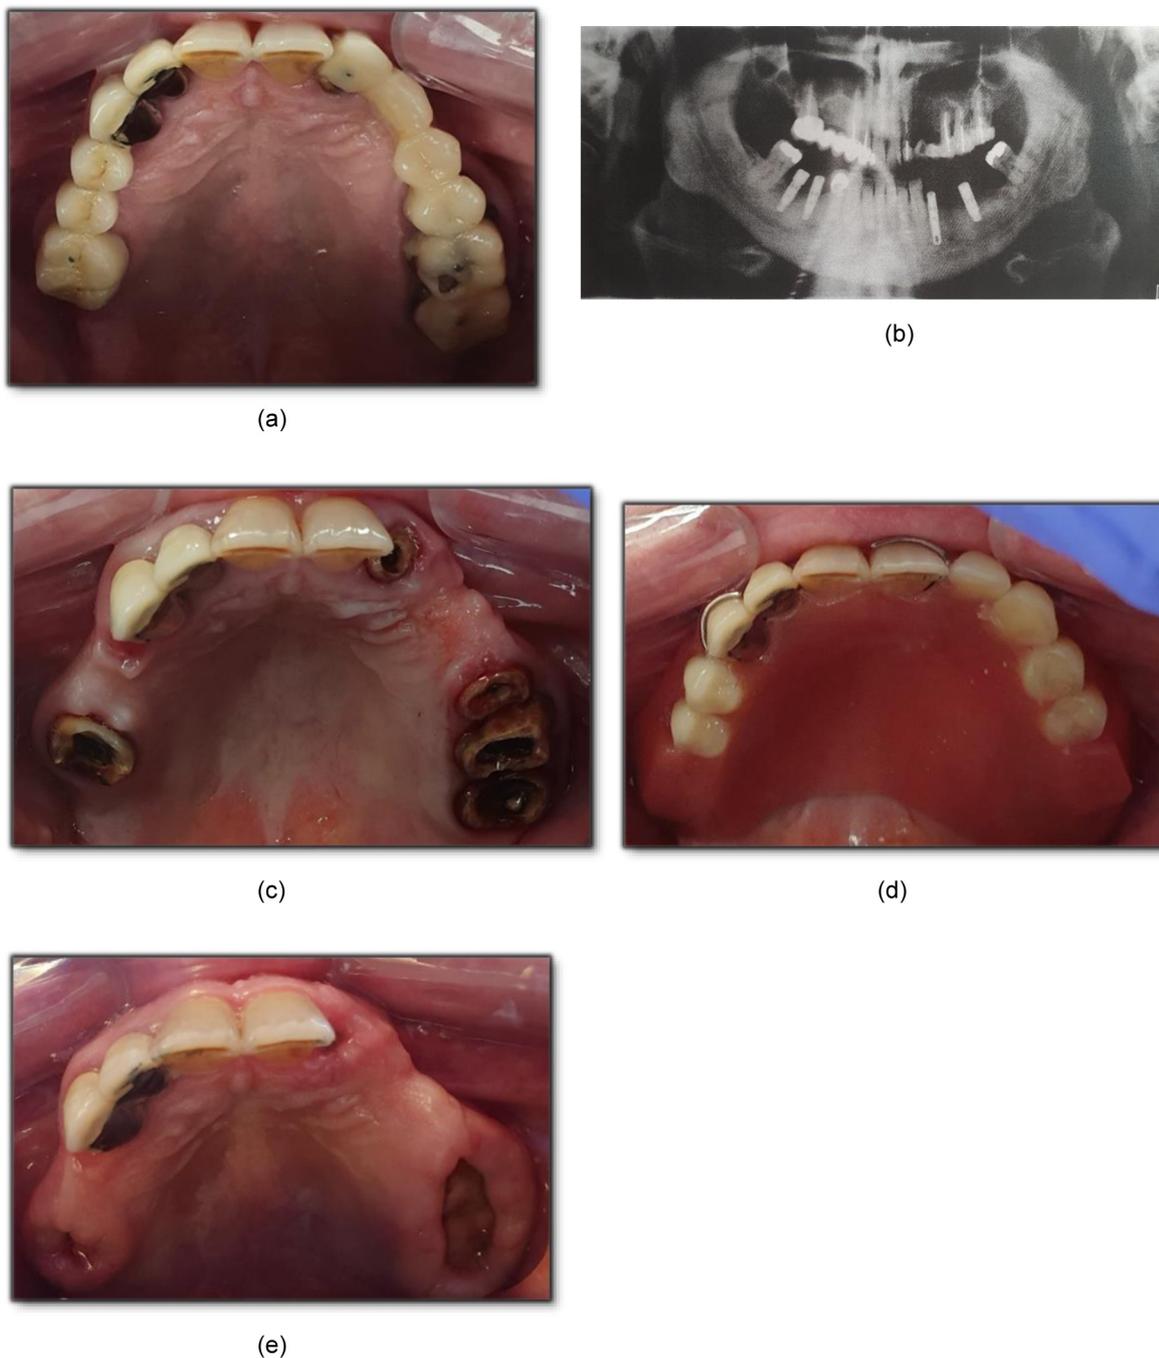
Iconographies of the clinical case. (a) Intraoral photograph in preoperative. (b) Orthopantomogram. (c) Maxillary occlusal view in peroperative. (d) Removal partial denture. (e) Postoperative view.
